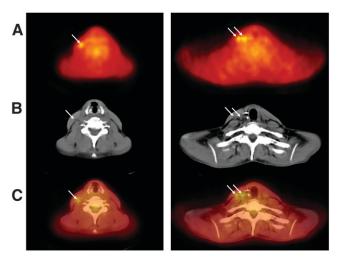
A 47-y-old woman with history of papillary thyroid cancer who underwent thyroidectomy and radioiodine ablation. Two years later, patient presented with thyroglobulin level of 6.1 ng/mL (TSH suppressed) and negative findings on ¹³¹I WBS. ¹⁸F-FDG PET (A) demonstrates small foci of increased ¹⁸F-FDG uptake (arrows) corresponding to small lymph nodes in right lower neck on CT (B). These are clearly visualized on fused ¹⁸F-FDG PET/CT (C) and were subsequently proven to be thyroid cancer metastases.
